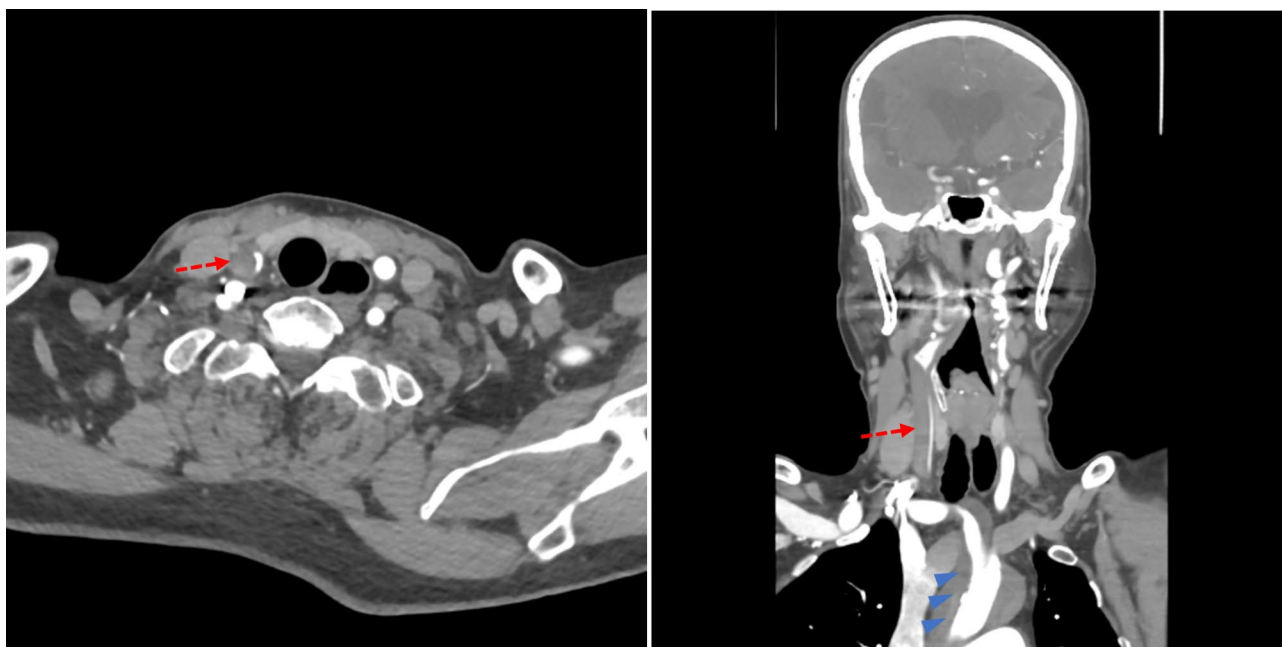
Brain CT angiography. 1a and 1b show collapse (red arrow) of the right innominate artery and the right carotid artery. This caused the patient's mental change to stupor with left weakness due to the brain malperfusion. Also, a coronal view (1b) presents ATAAD (blue arrowheads)
